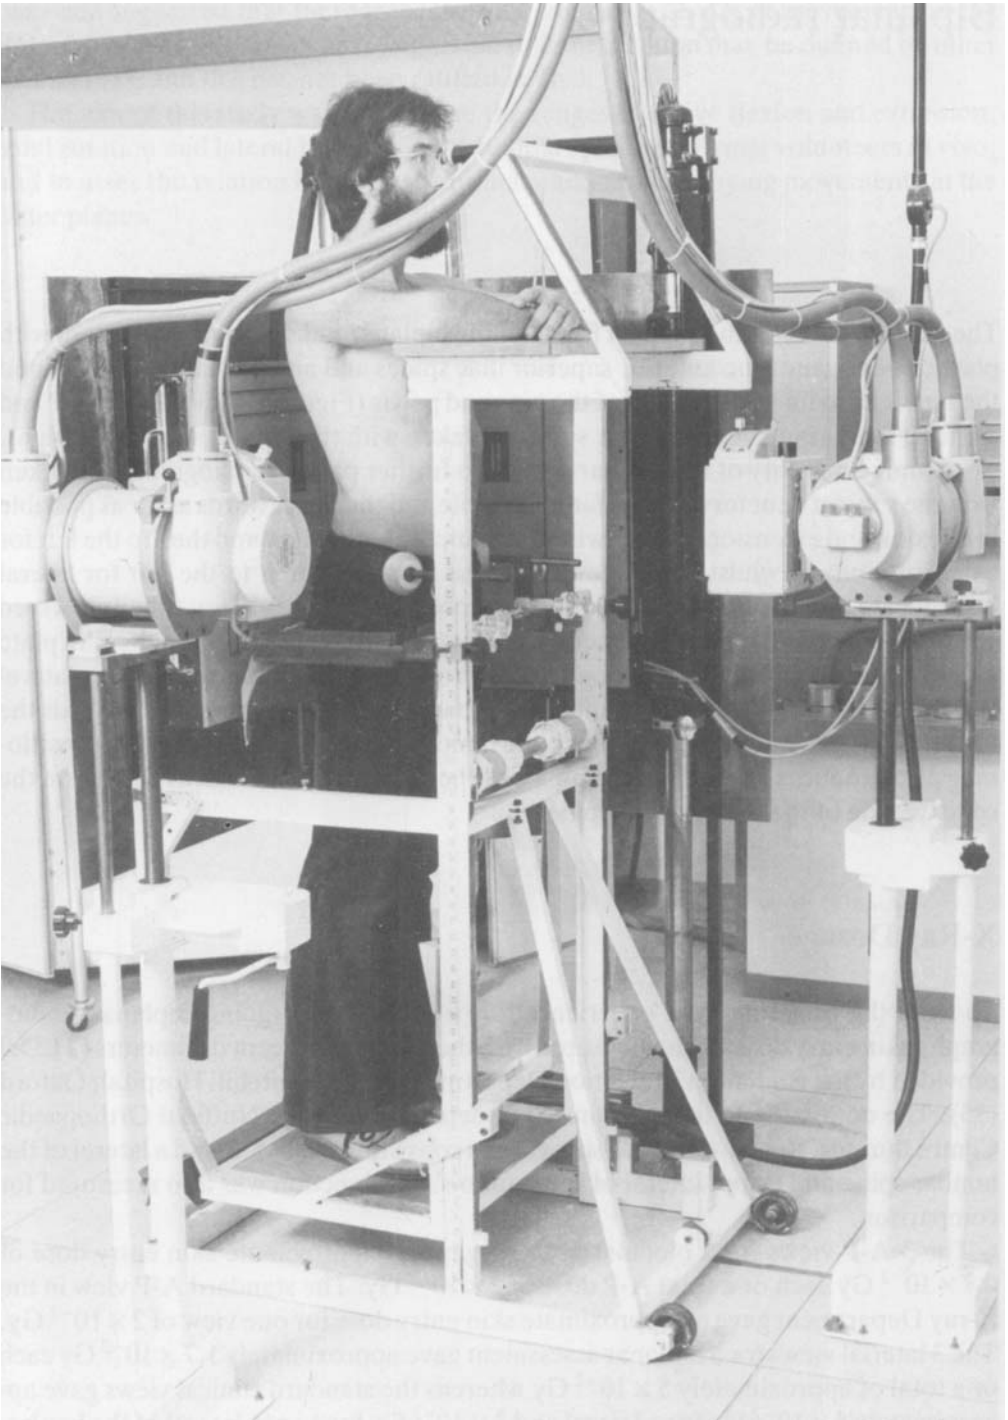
The biplanar rig showing a subject standing on an adjustable platform with X-ray tubes in front and to the side and with the film plates behind.
